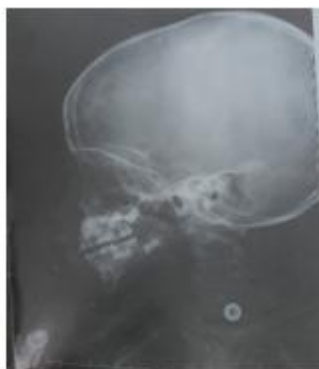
Absence of radiopaque foreign body on orbital radiography.
